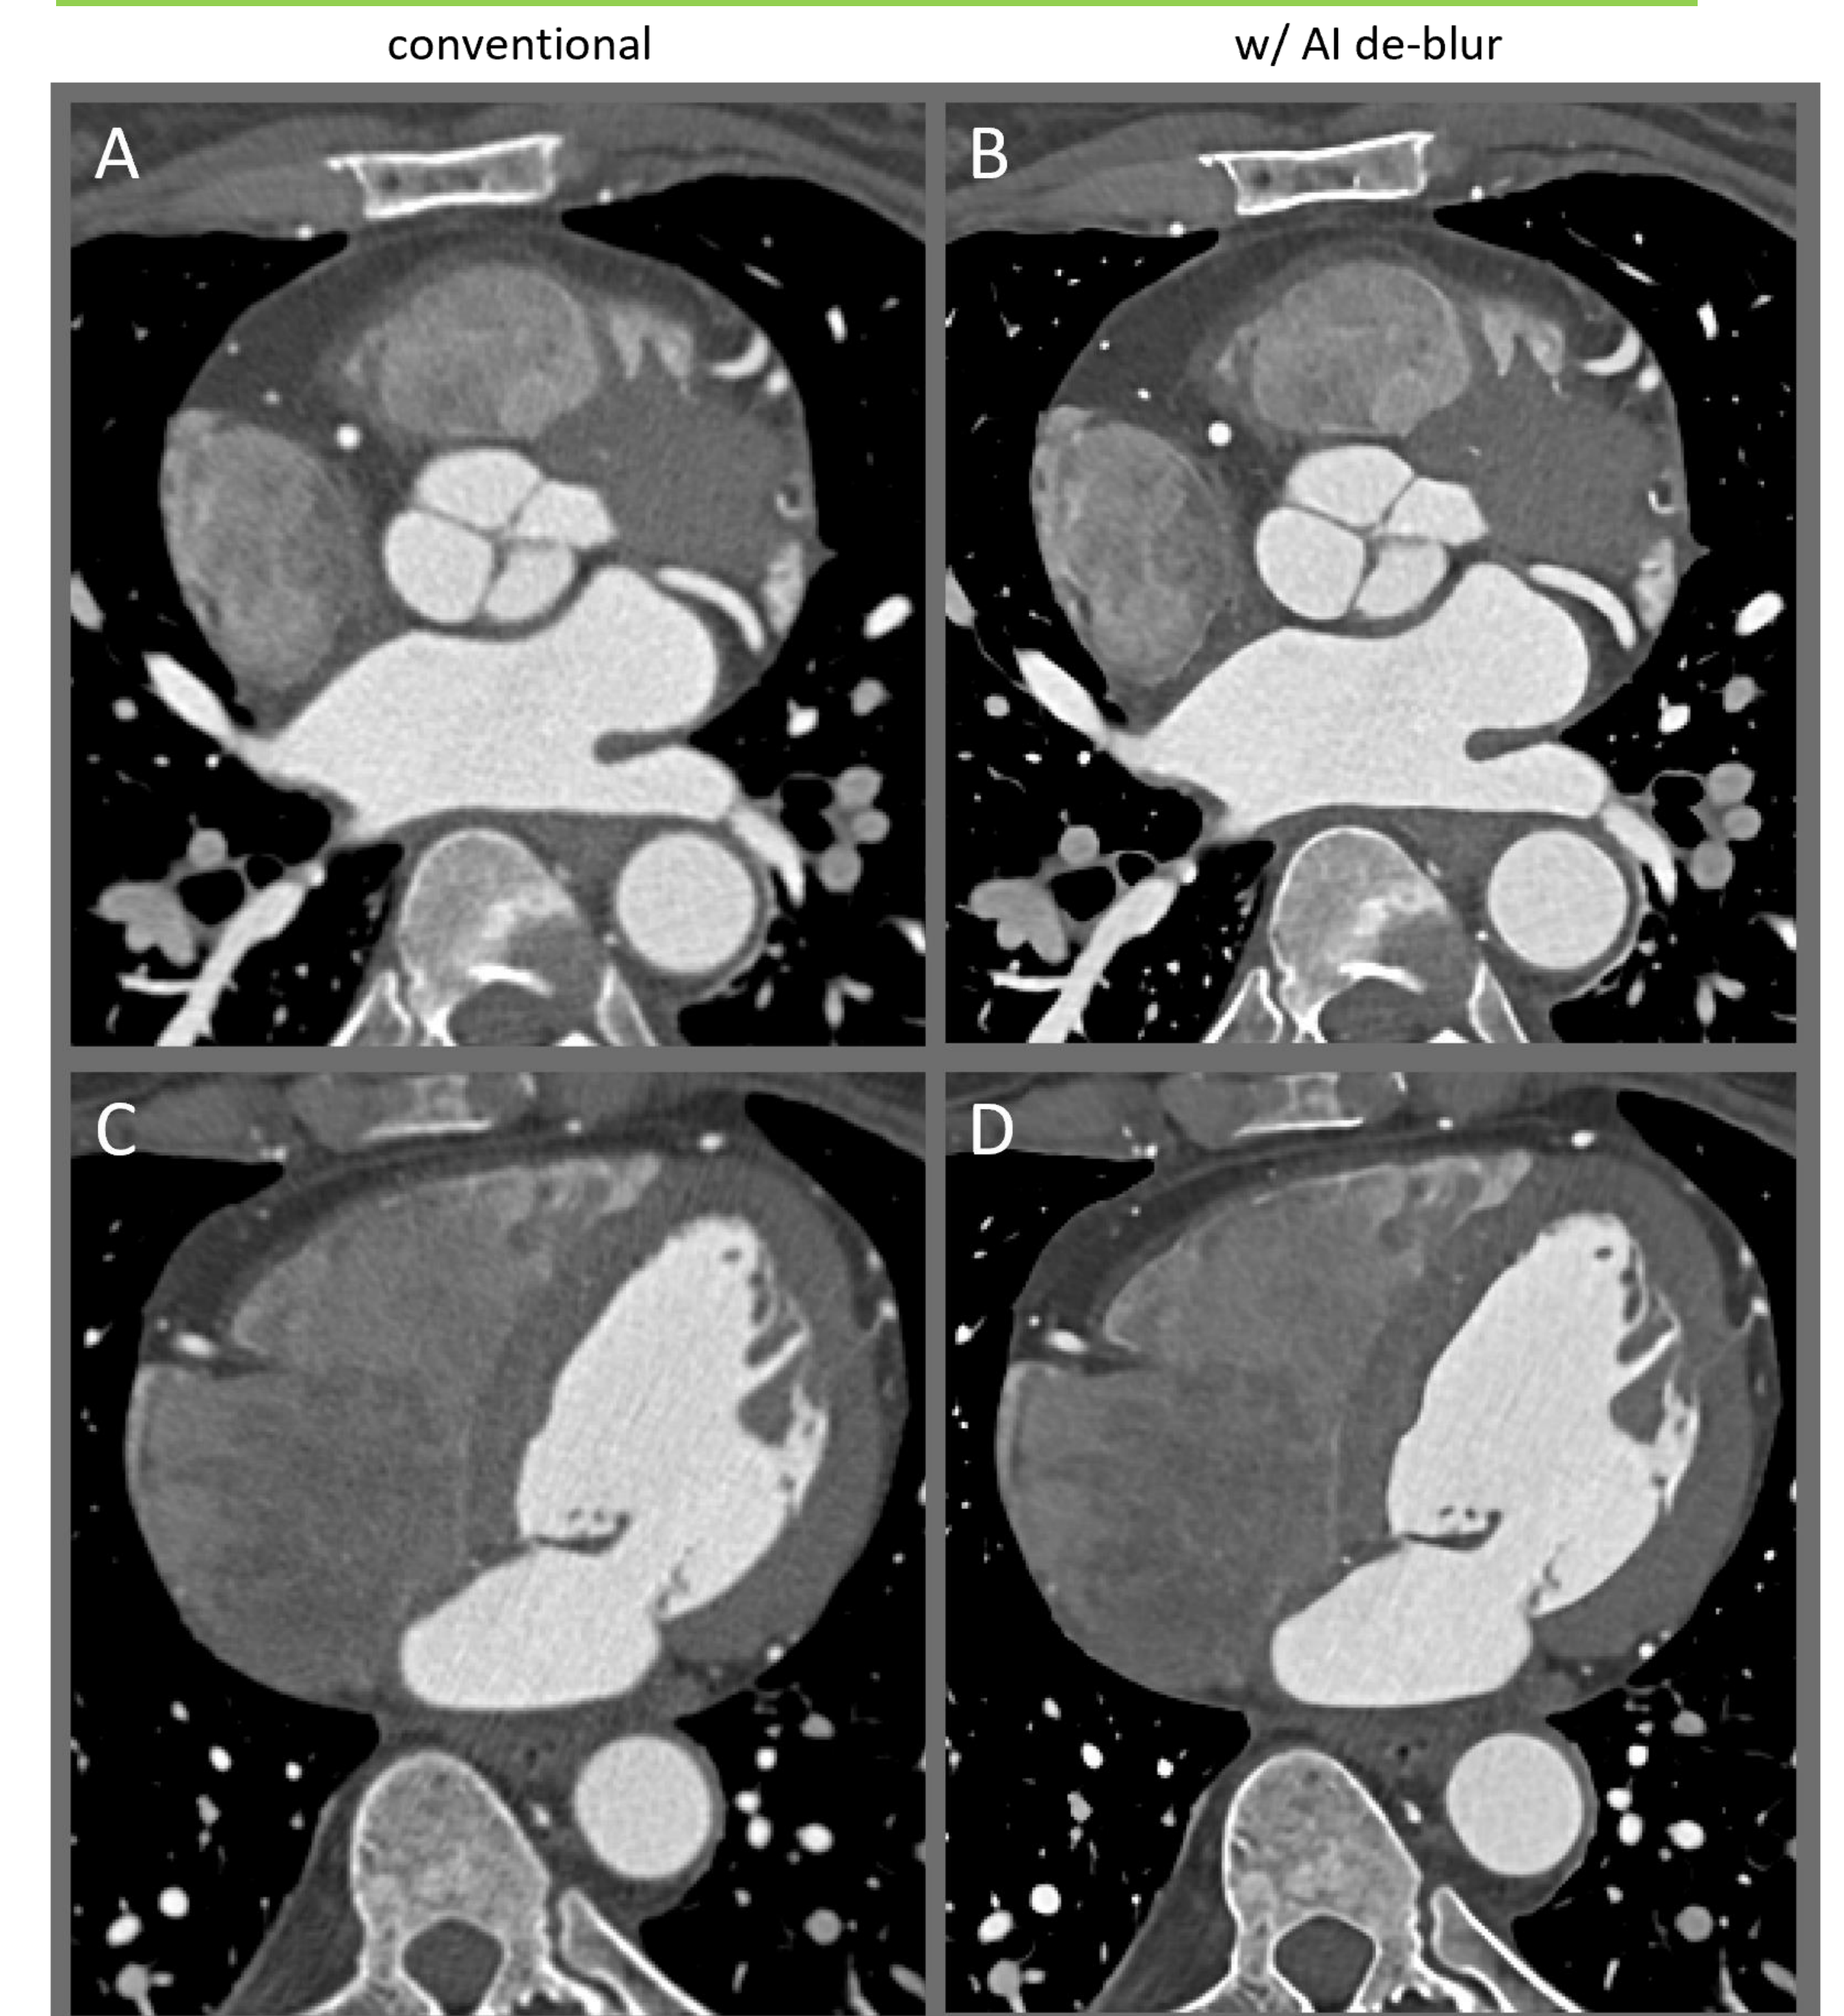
Gated cardiac CT acquisition shown at two different axial slice locations. A and B depict the same axial cross section with the conventional cardiac reconstruction shown in A compared to the DL-based image de-blurring method shown in B. C and D show a lower axial slice. Again, conventional processing in C is compared to the processing with DL image de-blurring active as shown in D.
